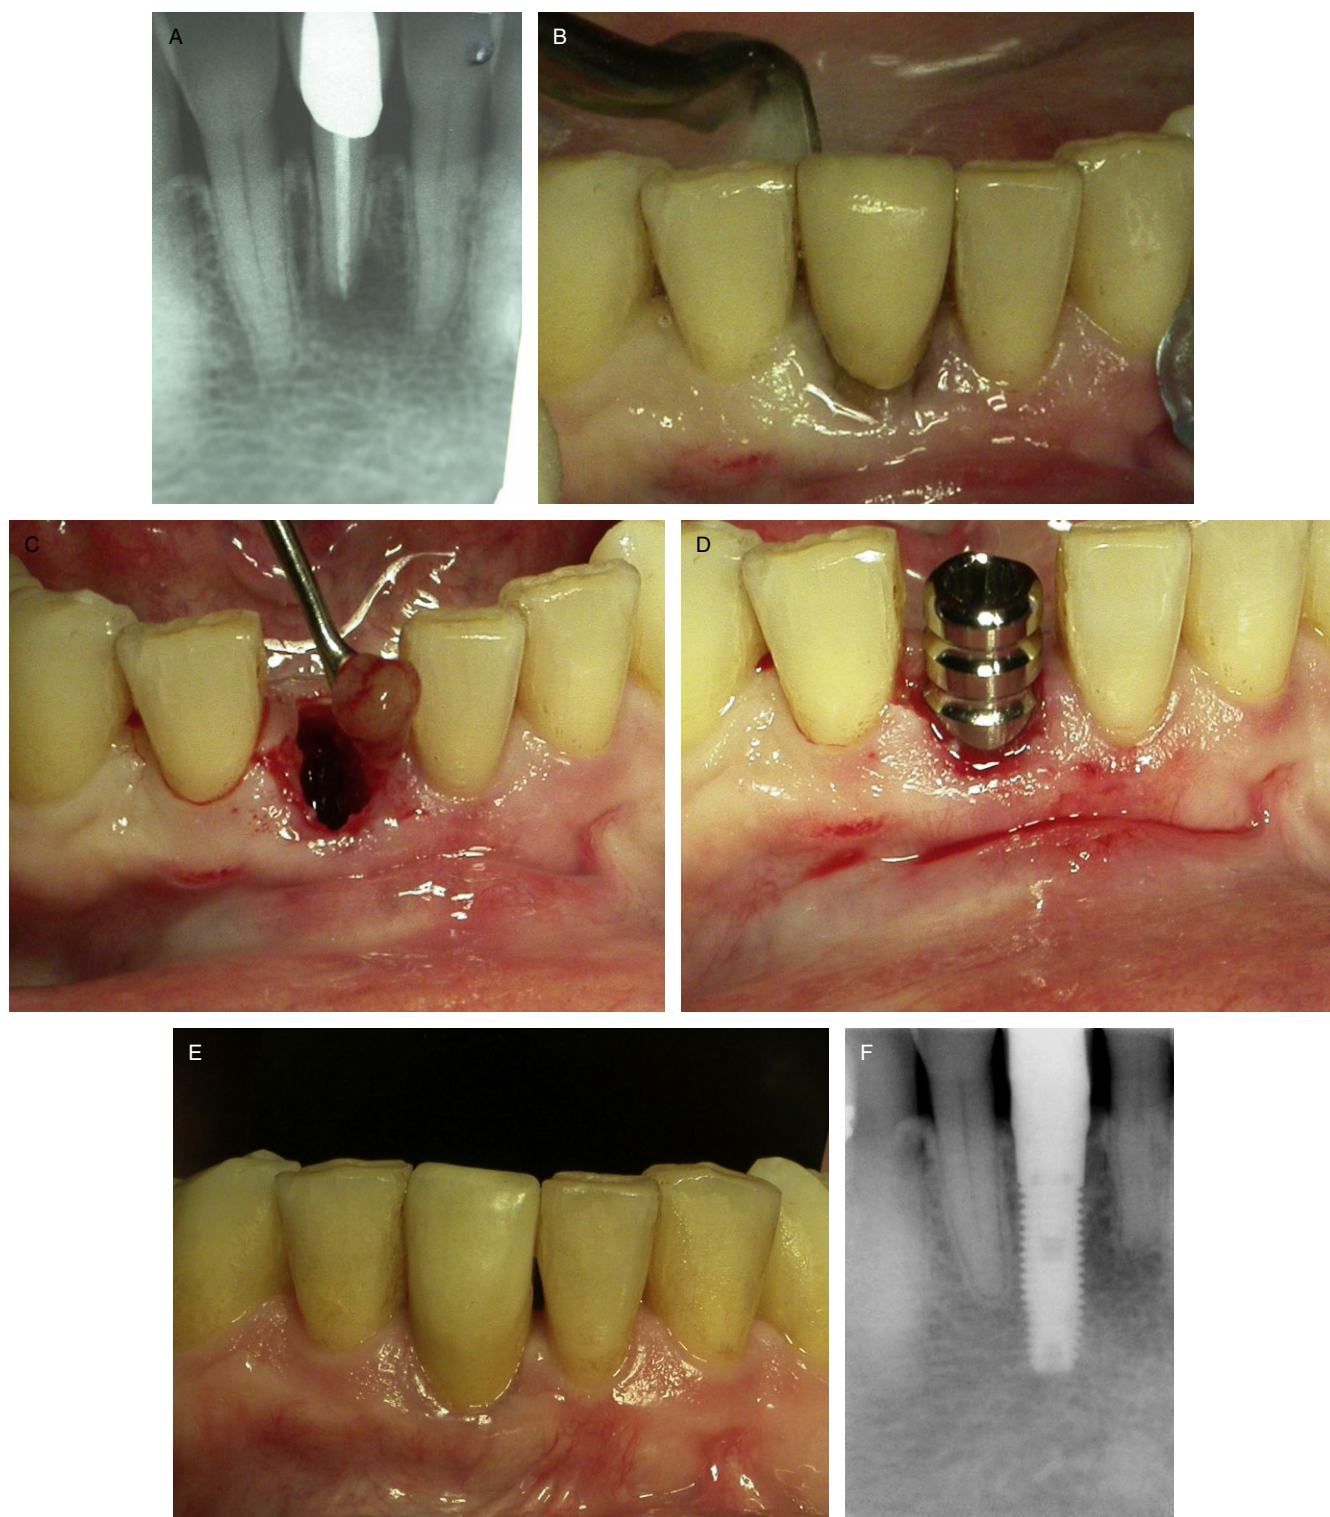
Treatment of an acute infected site with an immediate implant. *A*, Radiograph of the acute infected tooth that needs extraction. *B*, Cutting the periodontal ligament (PDL) fibers with the arrow-like tip on the lingual side. *C*, Pus cleaning of the acute infected site. *D*, Immediate implant placed. *E*, Clinical view at the 2-year control. *F*, Radiograph of the immediate implant at the 2-year control.
